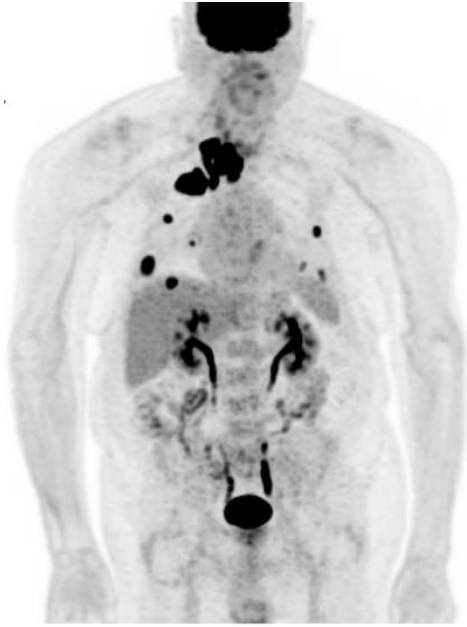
^{18}F -FDG PET/CT: Axial PET/CT fused image (*top right*) shows intense FDG-avid lesion in the right thyroidectomy bed. A small focus of FDG uptake lateral to this lesion corresponds to tumor thrombus in the superior vena cava/right internal jugular vein. MIP and axial PET/CT fused images (*bottom right*) show multiple FDG-avid lung metastases.
